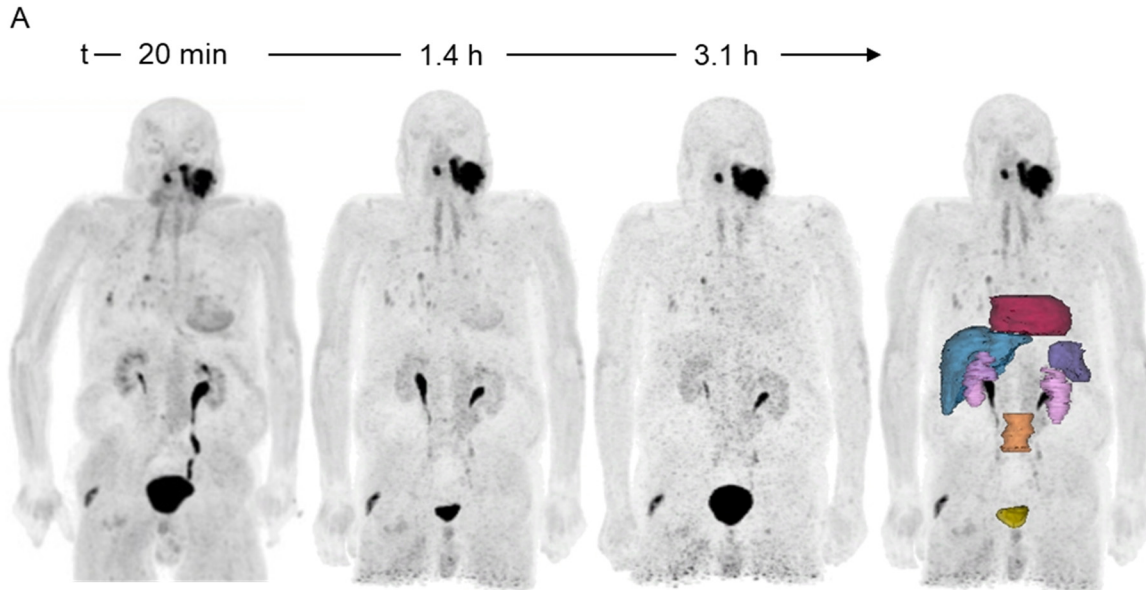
Patient 5 (Male) biodistribution. (A)  $^{68}\text{Ga}$ -FAPI-46 MIP and delineated organs for dose calculations, (B) SUVmax and (C) TBR at three timepoints following tracer injection. SUVmax and TBR for the bladder are excluded from the plot.
